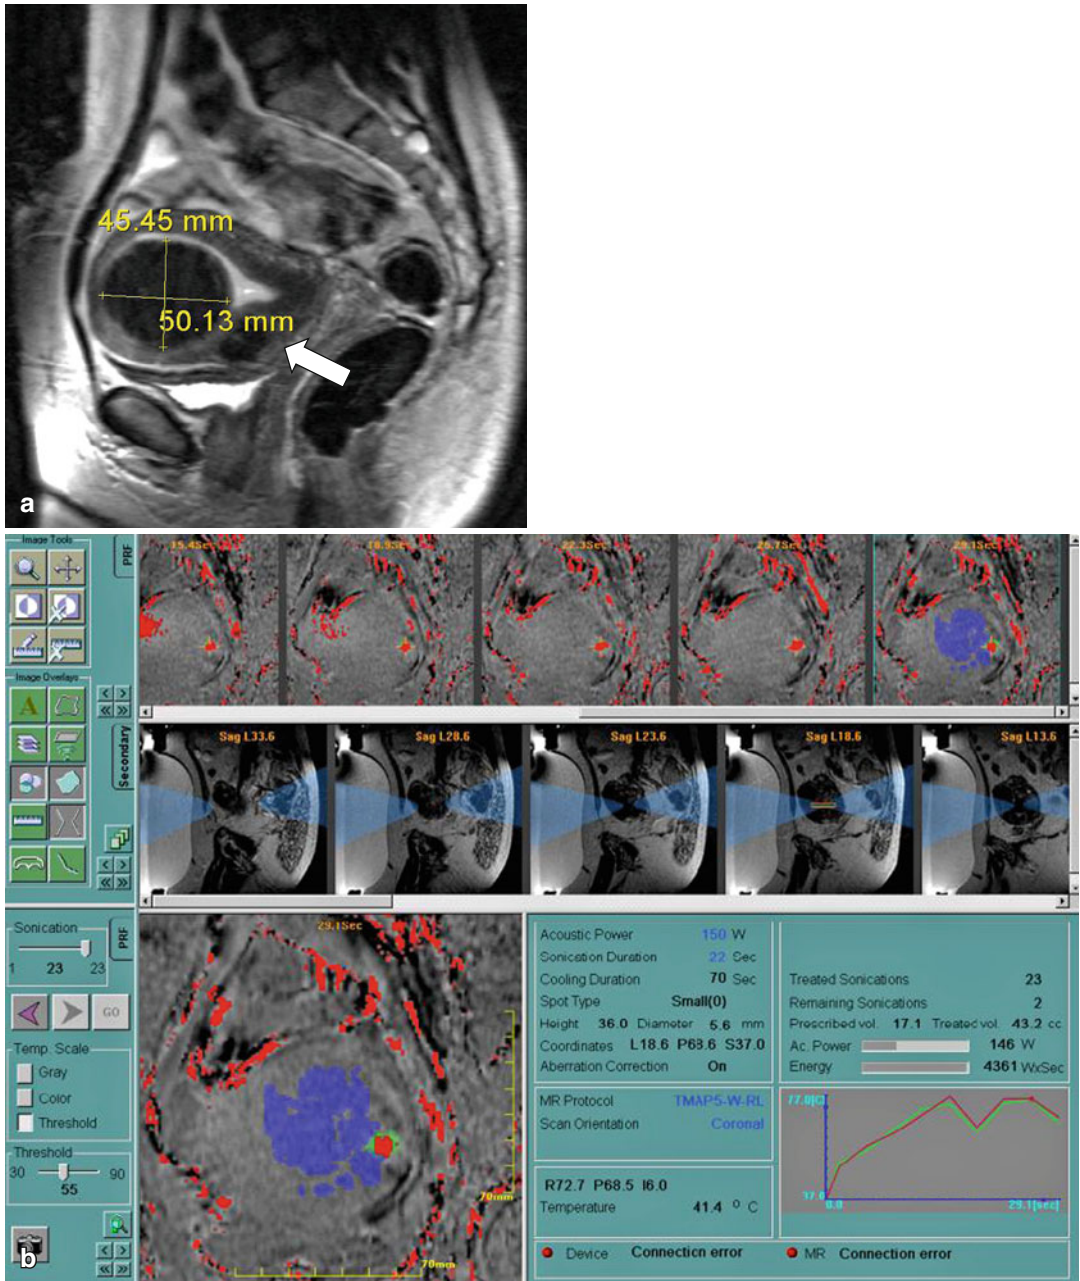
(a) Pretreatment T2-weighted sagittal image shows a large submucous fibroid of the uterus. In addition, a small intramural fibroid can be seen (white arrow). (b) Thermomapping during MRgFUS. Blue areas indicate the volume that has already been treated. The yellow and green dots show the ongoing sonication. The curve
